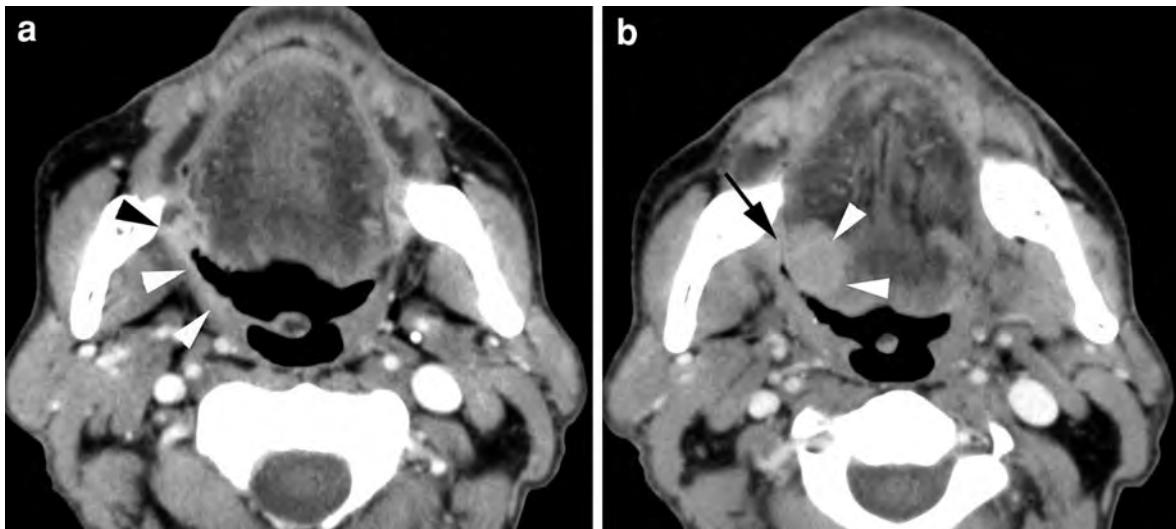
Axial contrast-enhanced CT images in a patient with *right-sided* tonsillar cancer. a Soft tissue thickening and increased enhancement is seen in the *right* anterior tonsillar pillar (*white arrowhead*), extending into pterygomandibular
